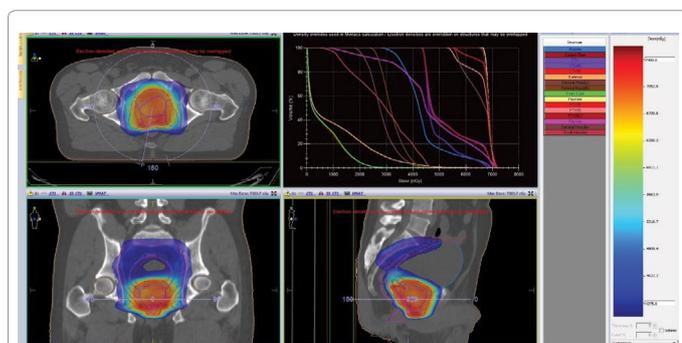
An example of a treatment plan VMAT technique - dose distribution on the CT image and dependence of the volume of the areas as a function of dose.
